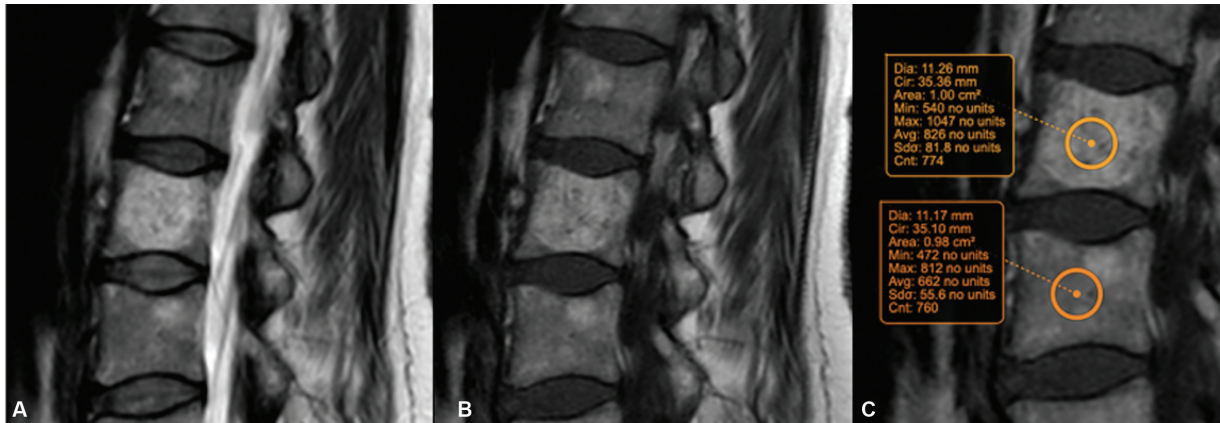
Sagittal T2- (A) and T1-weighted (B, C) images from the normal cohort with a typical hemangioma in L3 vertebral body showing calculation of T1 ratio of marrow of the hemangioma/ normal marrow. The ratio is $826/662 = 1.24$.
